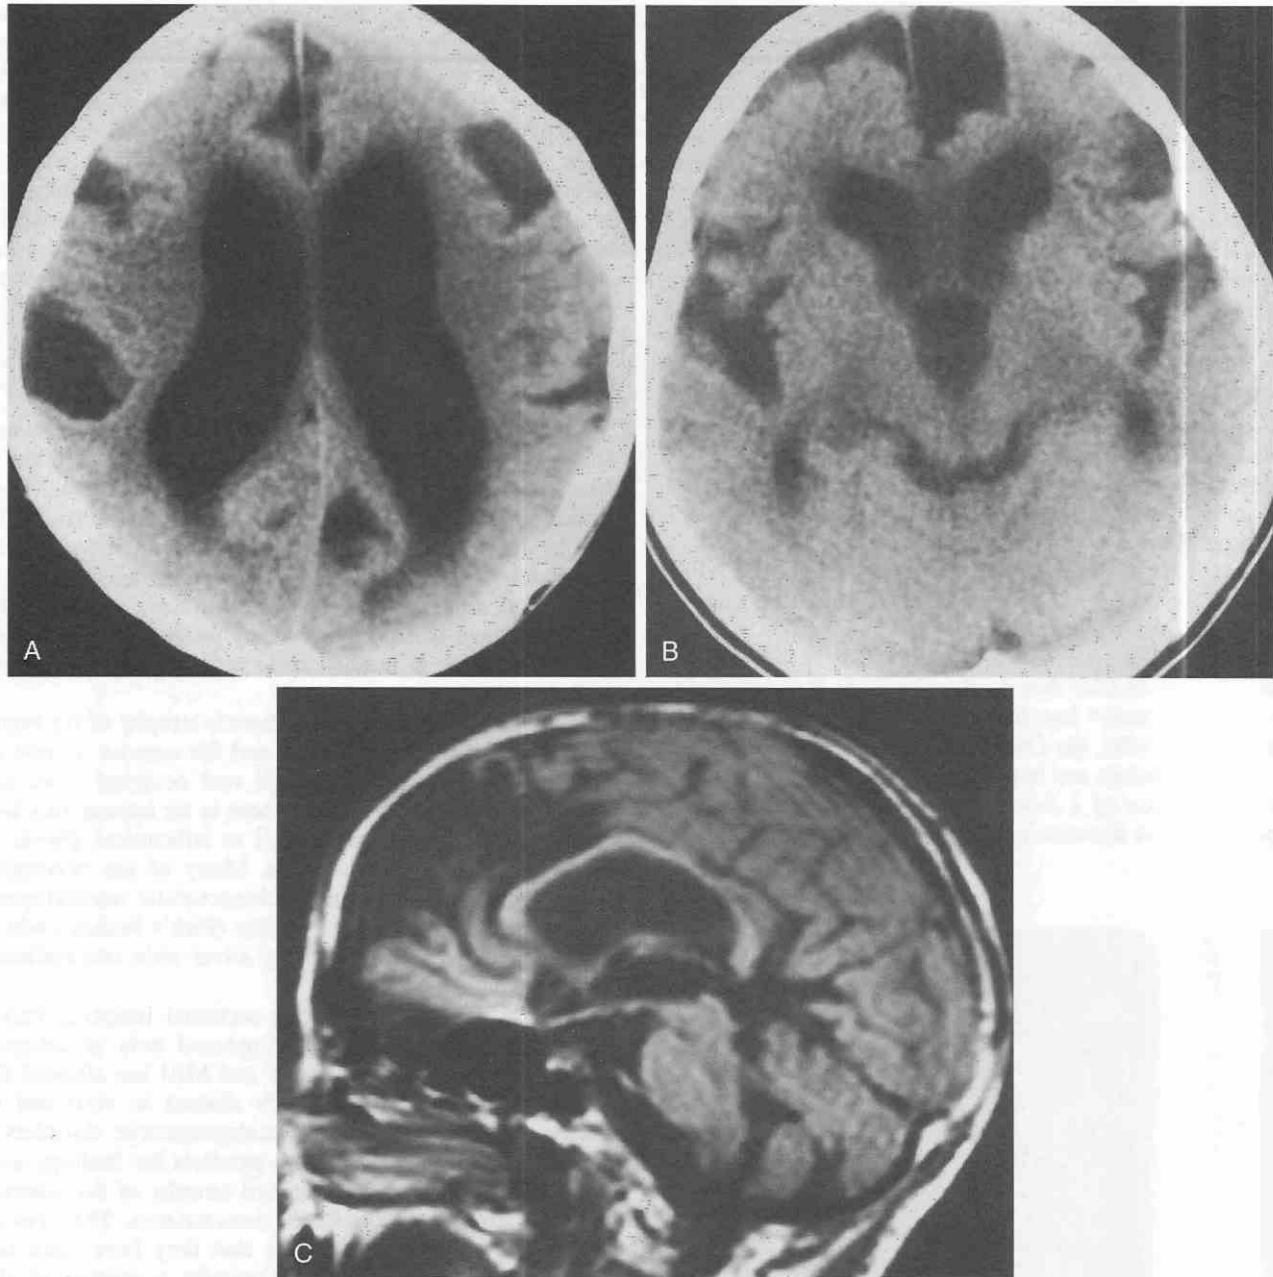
Shunt-proven normal-pressure hydrocephalus in a patient with prominent focal sulcal dilatation. Axial CT scans through the bodies of the lateral ventricles (A) and third ventricle (B) and midsagittal MR image (C) demonstrate marked dilatation of the lateral ventricles. The temporal horns are moderately enlarged. The third ventricle is severely dilated and rounded. There is marked dilatation of the following sulci: the sylvian fissures bilaterally, the central sulci bilaterally, the anterior aspect of the interhemispheric fissure, the left parieto-occipital fissure and the left calcarine fissure. In addition, there is marked focal dilatation of the cingulate sulcus on the right, the precentral sulcus on the left, and the frontal sulci bilaterally. There is also dilatation of the suprasellar and quadrigeminal plate cisterns. The remaining sulci are compressed. There is no evidence of dilatation of the choroidal and parahippocampal fissures, hippocampal atrophy, or cerebellar or brain stem abnormalities. (From Holodny AI, George AE, de Leon MJ, et al: Focal dilatation and paradoxical collapse of cortical fissures and sulci in patients with normal-pressure hydrocephalus. *J Neurosurg* 89:742-747, 1998.)
